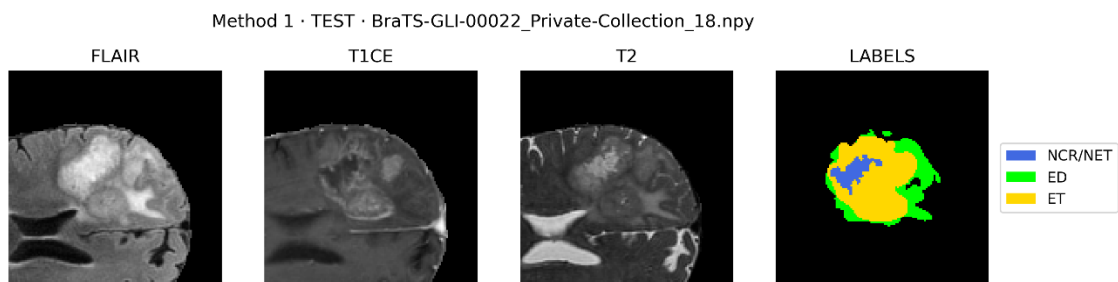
Example of FLAIR, T1GD, and T2 slices from the test set, with the corresponding segmentation labels showing necrotic core, ED, and enhancing tumor.
